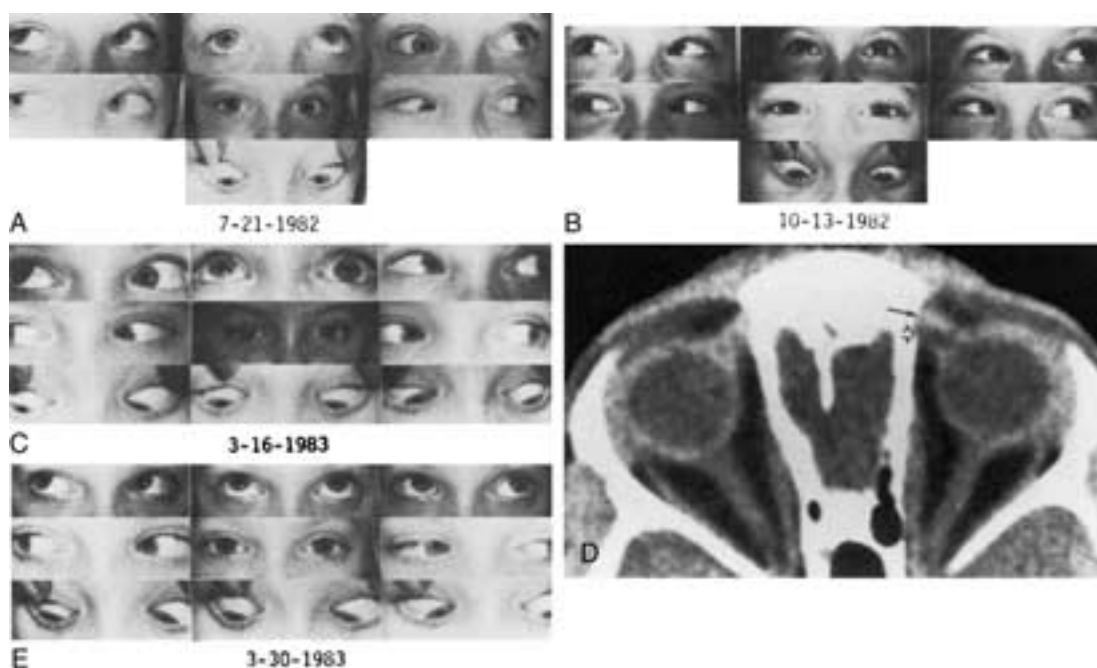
A, Congenital Brown syndrome showing the eyes in various gazing positions. Note the markedly limited elevation of the right eye in the upward midline position (*top middle*), which is even more pronounced on adduction of the right eye (*top right*). B, Eleven months after tenotomy of the right superior oblique muscle, elevation is markedly improved on both adduction and abduction. C, Acquired Brown syndrome developed on the opposite side following trauma. Note the limited elevation of the left eye in the straight-up position (*top middle*) and during adduction (*top right*). D, Axial CT scan demonstrates slight thickening of the reflected portion of the left superior oblique tendon (*arrow*). The open arrow points to area of edema. E, After 2 weeks of steroid therapy, elevation is markedly improved on both adduction and abduction. (From Mafee MF, Folk ER, Langer BG, et al.: Computed tomography in the evaluation of Brown syndrome of the superior oblique tendon sheath. *Radiology* 1985;154:691–695.)
